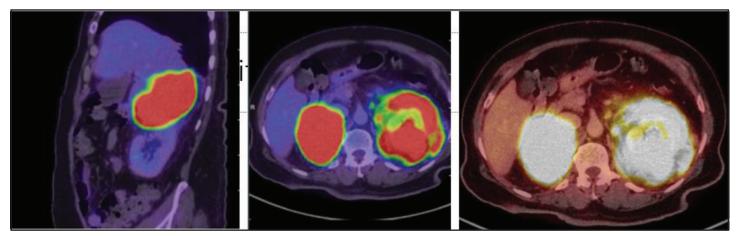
FDG PET: FDG avid mass lesions involving the right suprarenal region and the left kidney.
